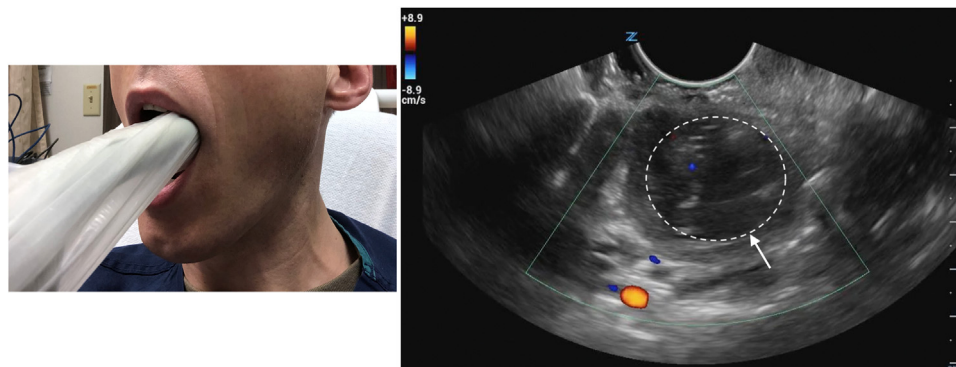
Intraoral ultrasound demonstrating peritonsillar abscess (white-dashed line with white arrow).
